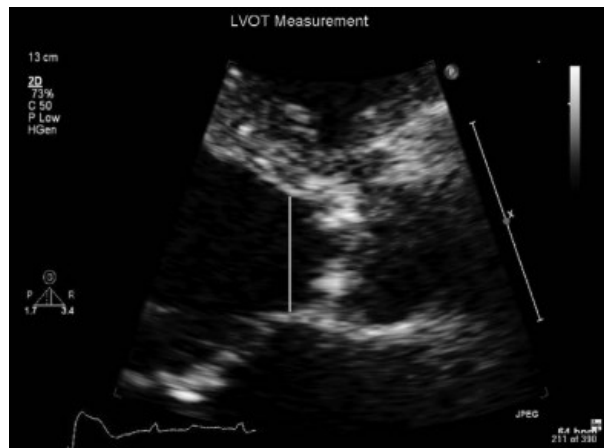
LVOT diameter measured in the parasternal long-axis view. Adapted from Baumgartner et al. J Am Soc Echocardiogr 2009;22:1-23; quiz 101-2 ⁽¹⁷⁾.
